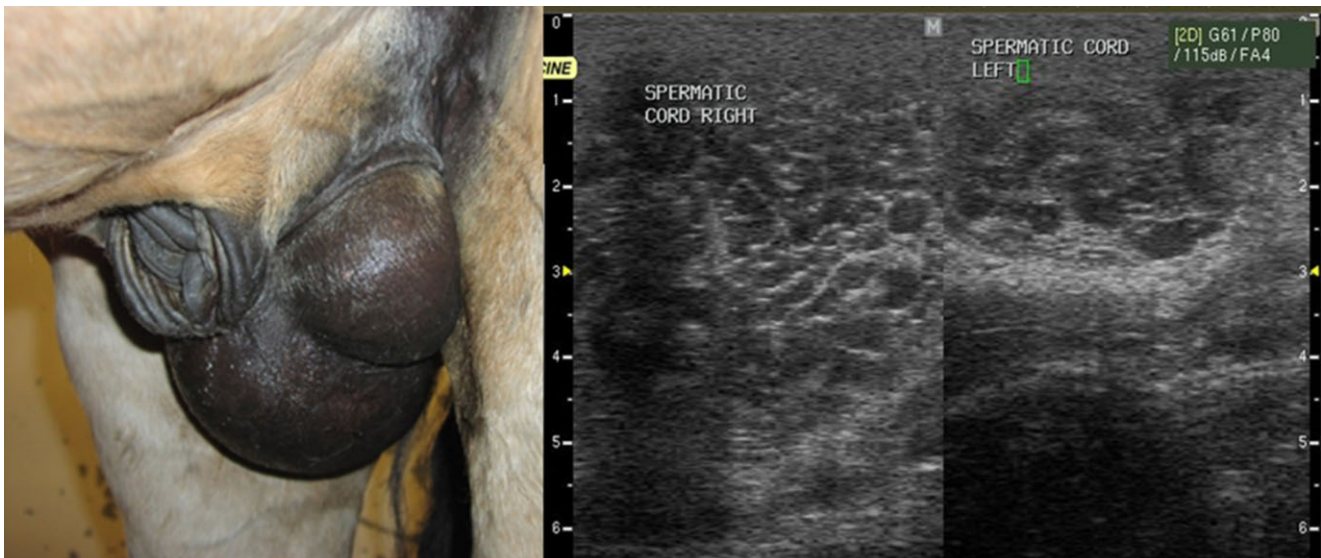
Unilateral scrotal enlargement in a stallion as a result of a seminoma. Scrotal ultrasonography revealed an enlarged right spermatic cord with several dilated vessels in the pampiniform plexus. In addition, a sizeable mass was palpated in the area of iliac lymph nodes indicating metastasis to at least the abdominal cavity.
